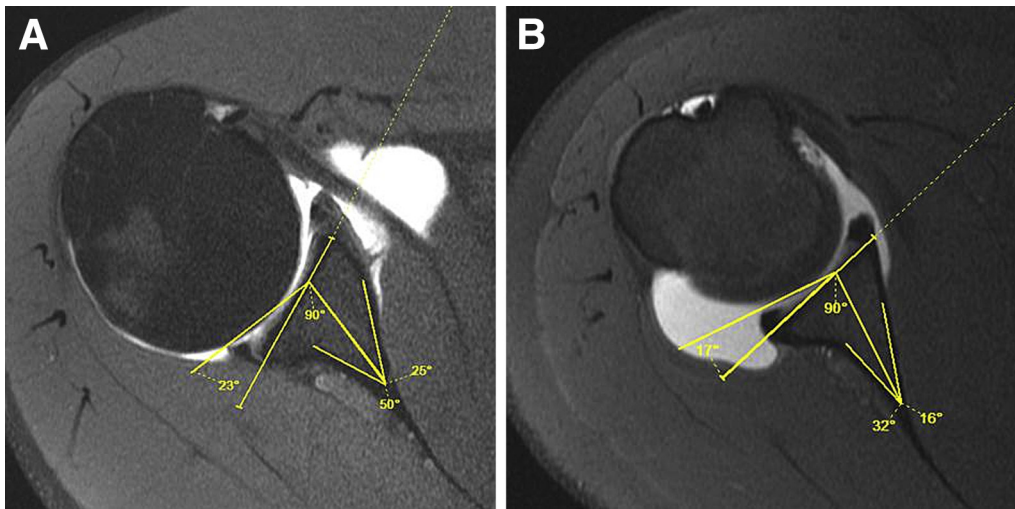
Measurement of glenoid retroversion on axial magnetic resonance images with the glenoid vault method.^{20,22} (A) Right shoulder with atraumatic posterior instability and 23° of glenoid retroversion. (B) Right shoulder with traumatic posterior instability and 17° of glenoid retroversion. In the glenoid vault method, a line is drawn from the medial corner of the endosteal vault, equally bisecting the isosceles triangle, which marks the glenoid vault. Another line is drawn perpendicular to this to define the line of neutral version. A line is then drawn parallel to the glenoid endosteal face, and the angle at which these 2 lines bisect is the angle of glenoid version.
